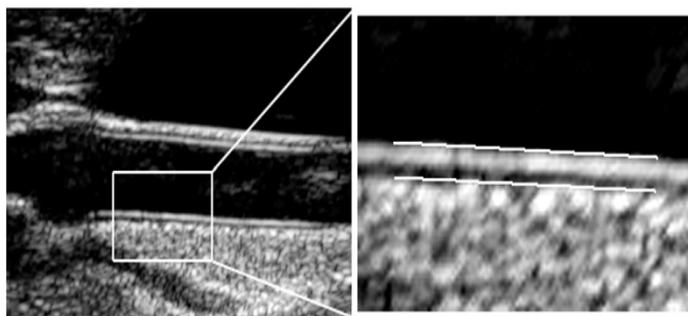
2D Ultrasound Image of Common Carotid Artery. The rectangular sector in the left hand panel is magnified and shown in the right hand panel. The distance between the lumen-intima interface (top white marking in right hand panel) and the media-adventitia interface (bottom white marking) is measured to provide CIMT.
